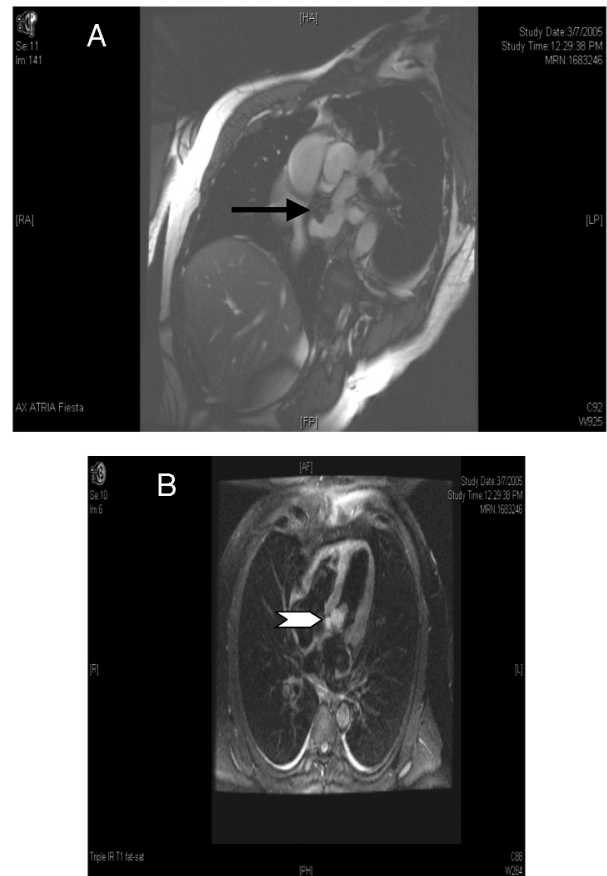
A and B depict T1- and T2-weighted cardiac magnetic resonance imaging, respectively. The left atrial (arrow) and left ventricular outflow tract tumor (arrow head) is revealed.
